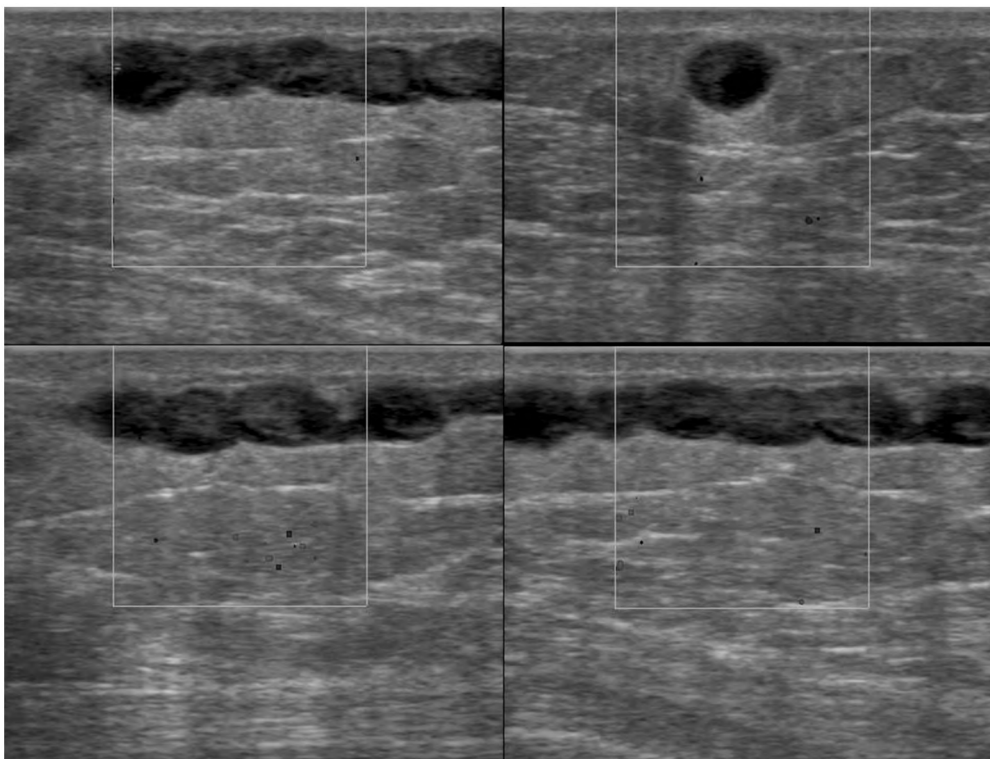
64 year old woman presented with a palpable painful mass at axillary tail. Sonogram of the palpable abnormality reveals a hypoechoic tubular structure of varying width and beaded appearance with no flow on color Doppler application. An occluded vein can be difficult to differentiate from a dilated duct.
